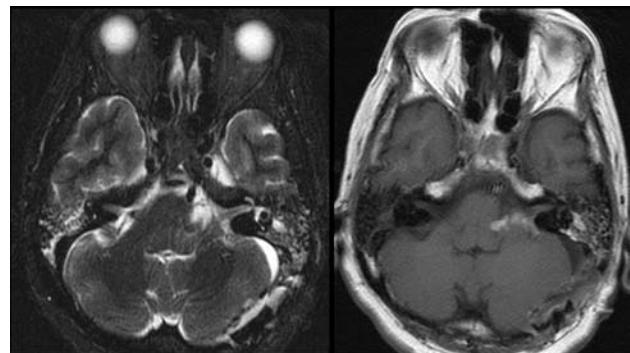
Brain MRI with gadolinium enhancement demonstrated a non-enhancing cystic (around 0.8×1.0 cm) lesion with diffusion restriction at the entry zone of trigeminal nerve and compression of the left brainstem, left V, VI, VII, VIII cranial nerves.
